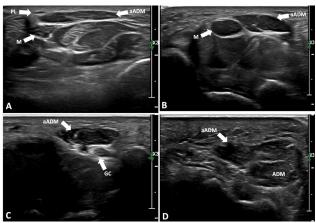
A, B, C & D – Ultrasound of the right wrist, with several images in axial plane progressively from proximal to distal and ulnar. Proximal to the carpal tunnel (A), a thin palmaris longus tendon (PL), normal appearance of the median nerve (M), and an accessory muscle belly in close relationship to these structures. At the carpal tunnel inlet (B), hypoechoic thickening of the median nerve, in close relationship with the accessory muscle belly. This muscle belly extends to the ulnar aspect of the wrist, crossing Guyon's canal (GC) volarly (C), and has a continuous course with the muscle belly of the abductor digiti minimi (ADM) (D). aADM - accessory abductor digiti minimi.
